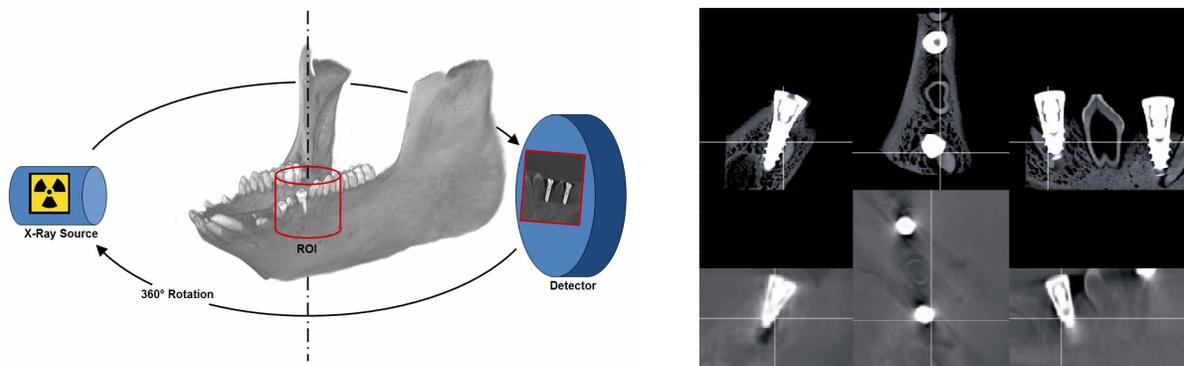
Left: Set up for dental CBCT (Accuitomo 60). The region of interest is marked in red. Right: For comparison, all tomography data were pre-registered via the manual selection of 3 non-collinear anatomical landmarks. (Top: μ CT Skyscan 1172; bottom: dental CBCT data).
